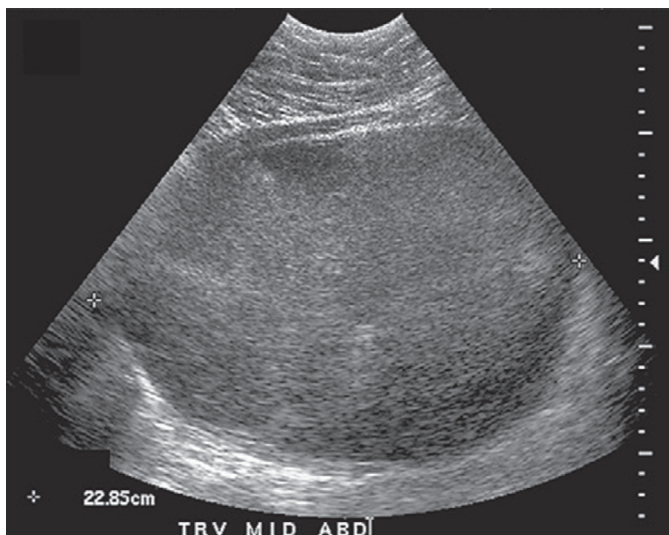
Ovarian torsion with a large pelvic mass. This transabdominal image reveals a largely homogeneous 22.8-cm pelvic mass. (From Cicchiello LA, Hamper UM, Scutt LM: Ultrasound evaluation of gynecologic causes of pelvic pain. *Obstet Gynecol Clin North Am* 38:85–114, 2011.)
